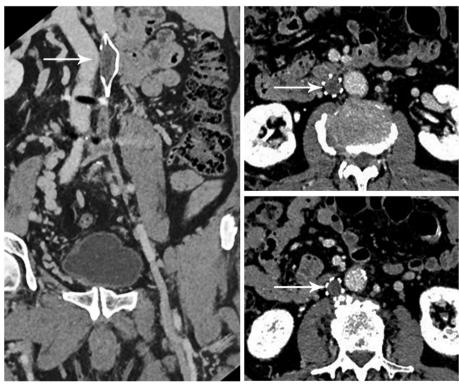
Venous CT angiography showing the chronically occluded filter-bearing IVC (arrow).
